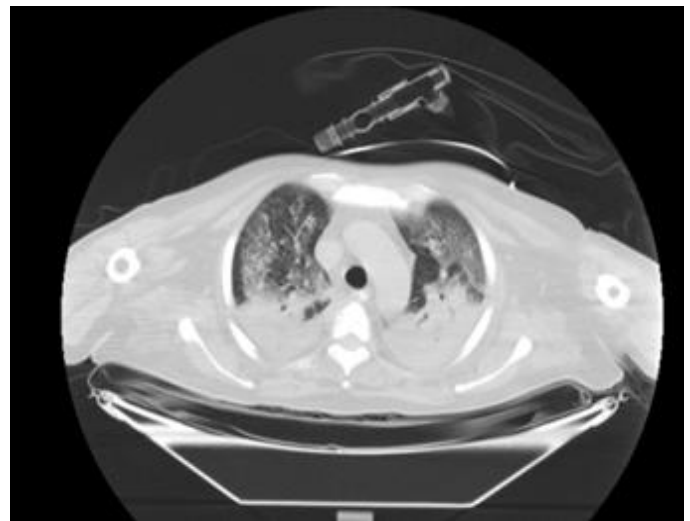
CT of lung showing Ground glass opacity.
